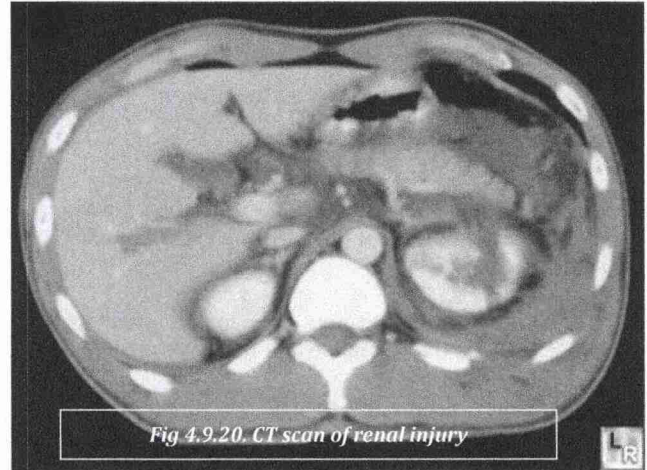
CT scan of renal injury
